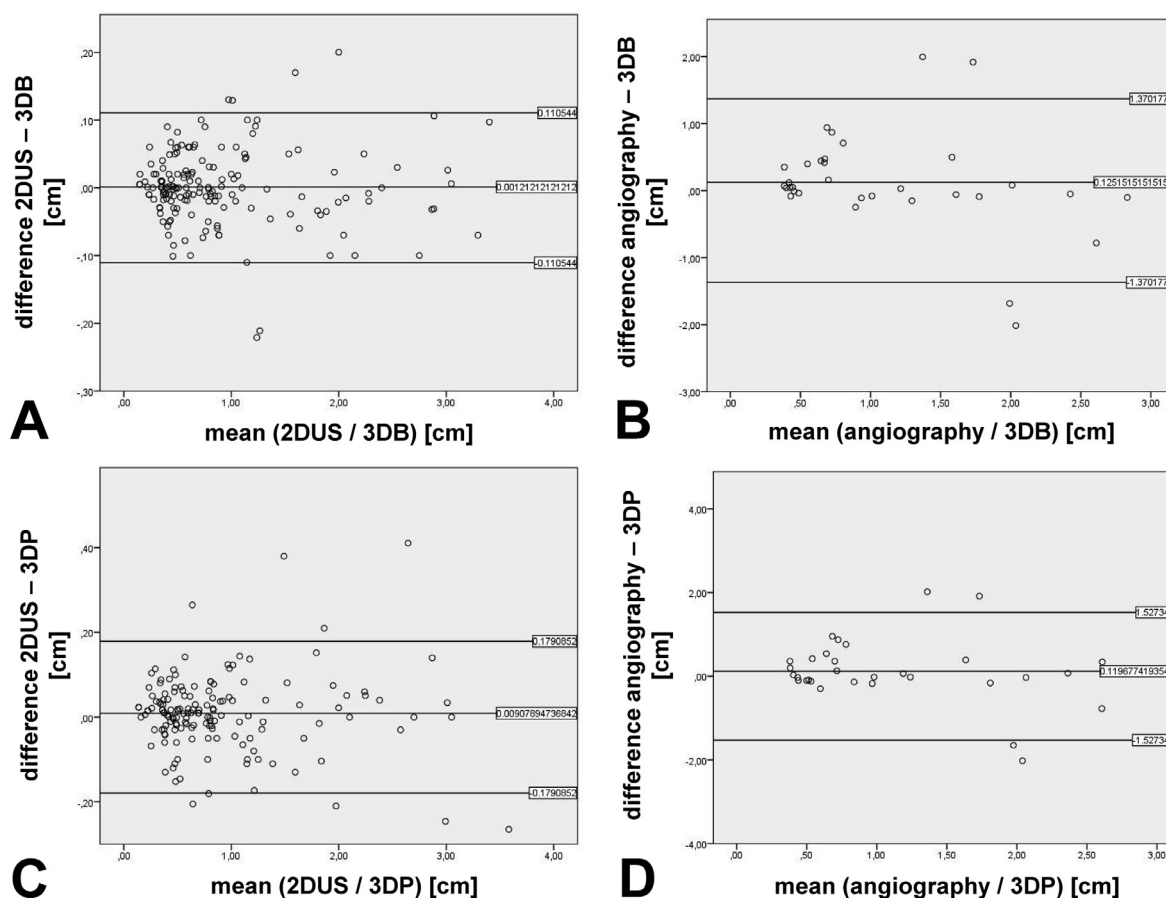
Bland–Altman plots for agreement between methods used. Every 3-D tomographic ultrasound (tUS) scan was compared with at least three corresponding measurements of the vessel diameter at distinct anatomic landmarks (e.g., the anastomosis region) to the results from the 2-D US or angiography. (a) Agreement between 3-D tUS based on B-mode (3-DB) and 2-D ultrasound for the measurement of different diameters within the arteriovenous fistula. The difference between 2-D US and 3-D B-mode tUS was +0.012 mm. (b) Agreement between 3-D tUS based on B-mode (3-DB) and angiography for the measurement of different diameters within the arteriovenous fistula. The difference between angiography and 3-D B-mode tUS was +0.091 mm. (c) Agreement between 3-D tUS based on power Doppler (3-DP) and 2-D ultrasound for the measurement of different diameters within the arteriovenous fistula. The difference between 2-D US and 3-D PD tUS was +1.11 mm. (d) Agreement between 3-D tUS based on power Doppler (3-DP) and angiography for the measurement of different diameters within the arteriovenous fistula. The difference between angiography and 3-D PD tUS was +1.20 mm.
